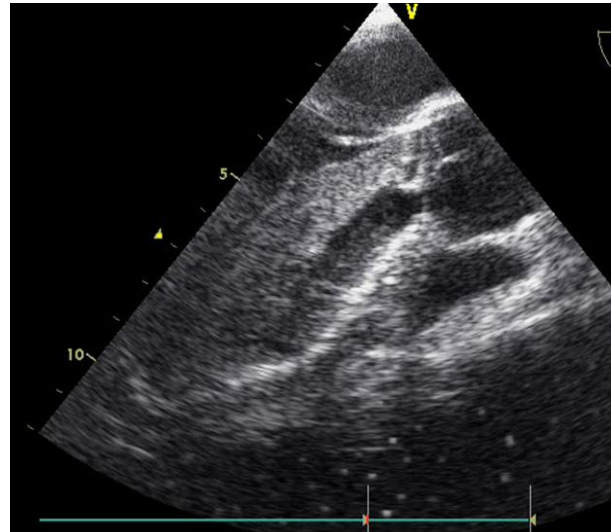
Transthoracic echocardiogram showing the left ventricular mass
